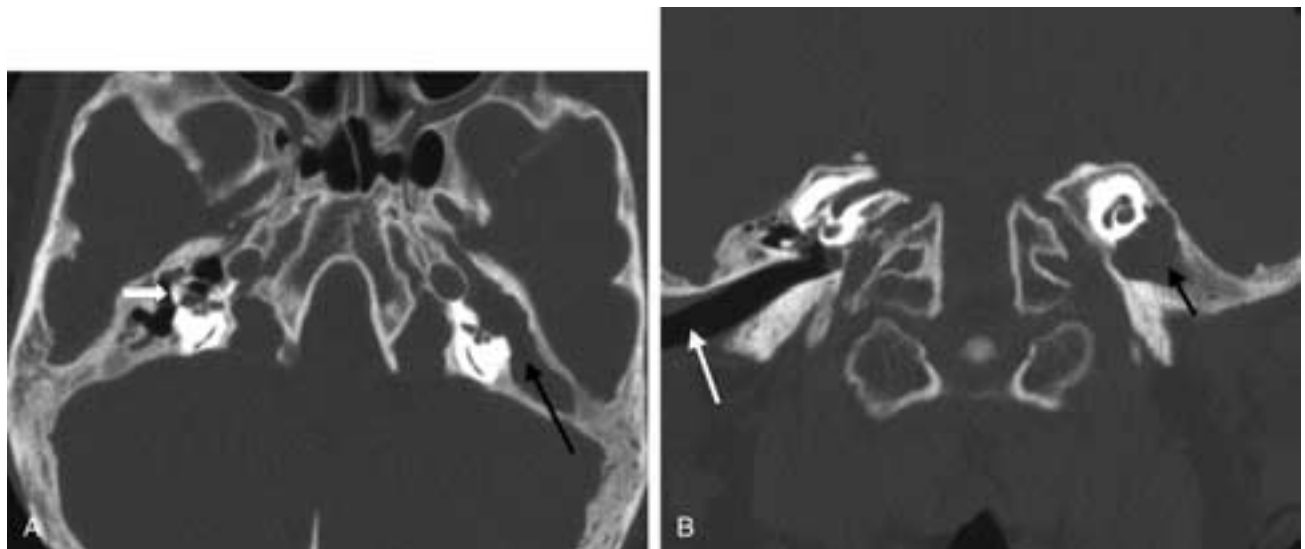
Achondroplasia. A, Axial CT image showing a congenital cholesteatoma on the left side (*black arrow*) and fused ossicles on the right (*white arrow*). B, Coronal CT image showing vertically oriented EACs (*white arrow*) secondary to hypoplasia of the central skull base and a left-sided cholesteatoma (*black arrow*).
